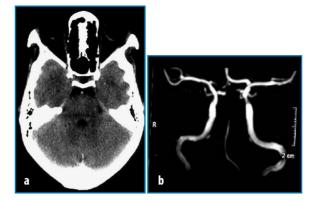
Cardioembolic acute basilar artery occlusion. a Noncontrast CT scan shows a spontaneous hyperdensity of the basilar artery. b MR angiogram shows the acute basilar artery occlusion
